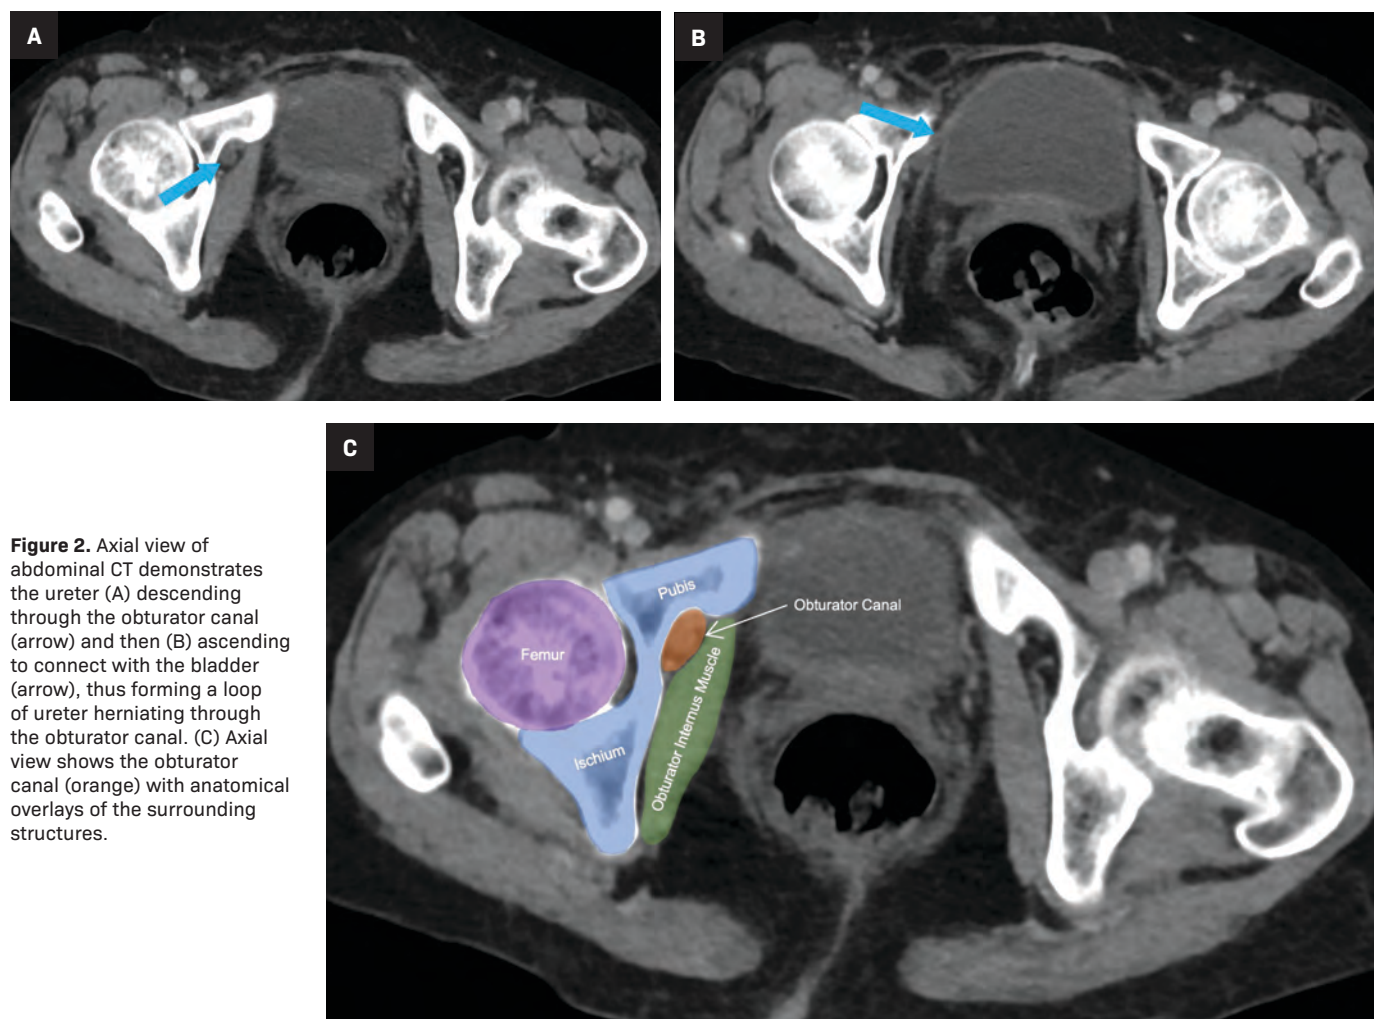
Axial view of abdominal CT demonstrates the ureter (A) descending through the obturator canal (arrow) and then (B) ascending to connect with the bladder (arrow), thus forming a loop of ureter herniating through the obturator canal. (C) Axial view shows the obturator canal (orange) with anatomical overlays of the surrounding structures.
